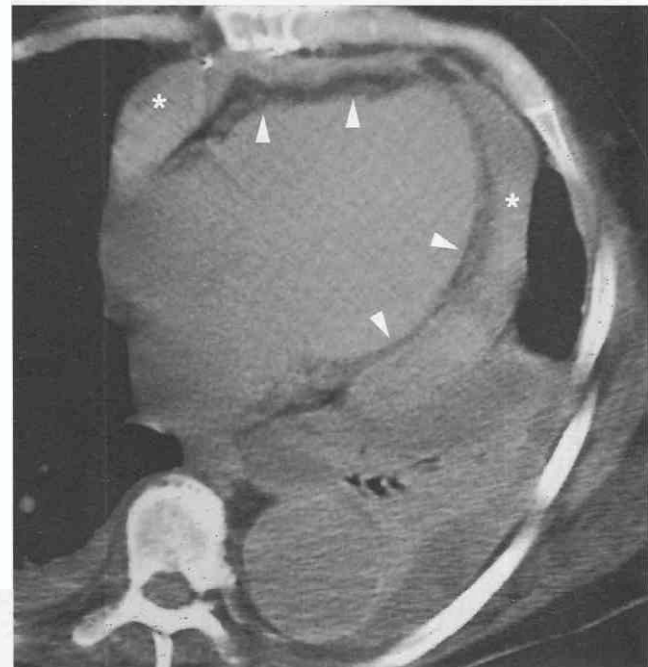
Hemopericardium in patient after coronary artery bypass graft surgery. Axial CT scan without contrast medium shows filling of the pericardial space (asterisks), which measured 59 HU, consistent with blood. The pericardial space is separated from the heart by a thin layer of subepicardial fat (arrowheads).
